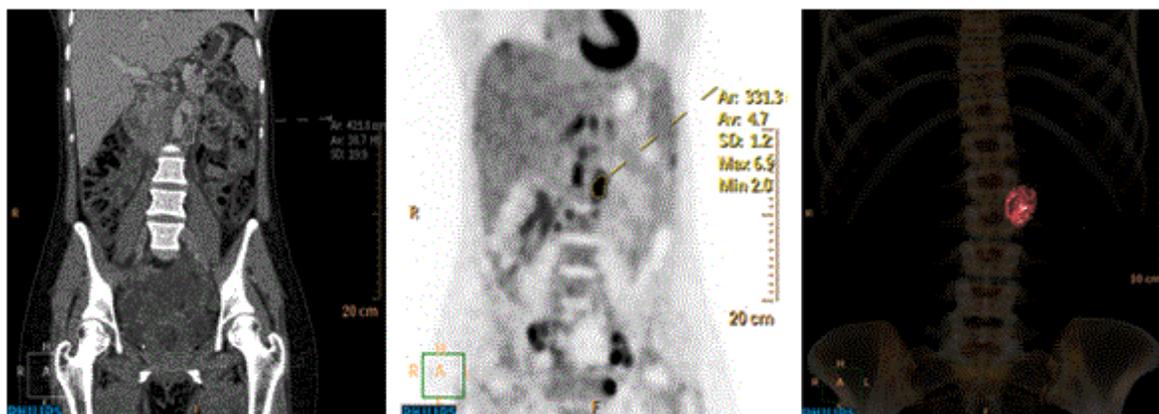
An example of lesion delineation (a) CT image (b) PET image (c) Extracted lesion volume using segmentation and its location
